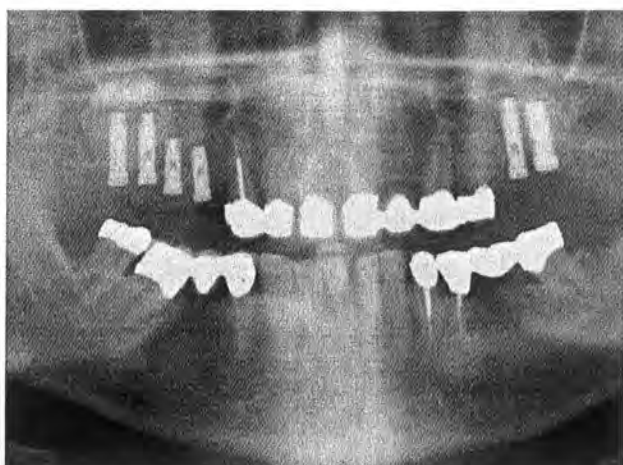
Preoperative panoramic x-ray.
